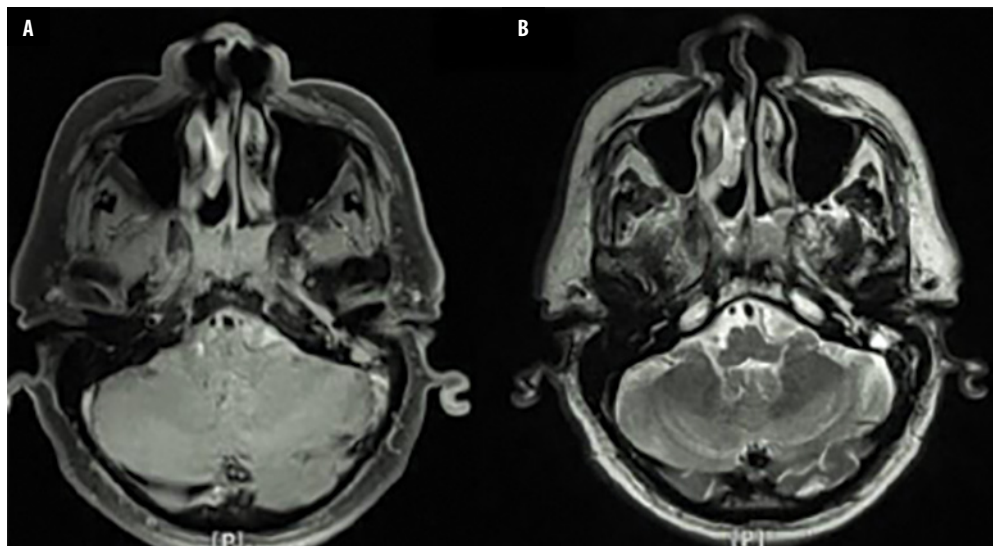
MRI T1 (A) iso-intense, and T2 (B) hyper-intense sections. There is heterogenous enhancement and thickening of the left fossa of Rosenmüller obliterating the left torus tuberosus and soft tissue density at right middle meatus obliterating the right osteomeatal complex
